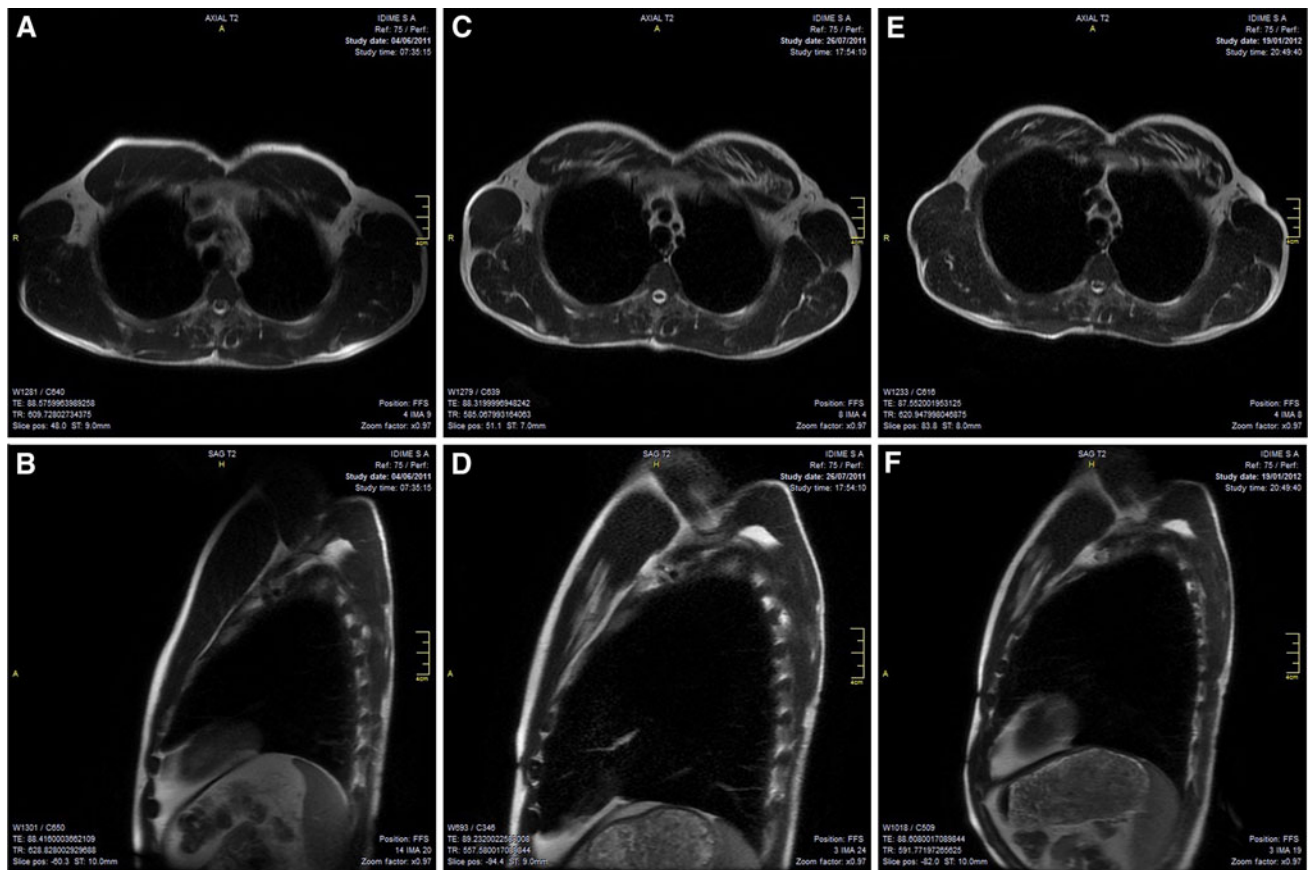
Chest magnetic resonance imaging (MRI): Report from a 42-year-old man who underwent dynamic-definition pectoral reshaping with fat grafting. In each pectoral zone, 200 ml of autologous fat was grafted in the sub- and intramuscular layers. a, b View before the procedure. c, d View 2 months after the procedure. e, f View
